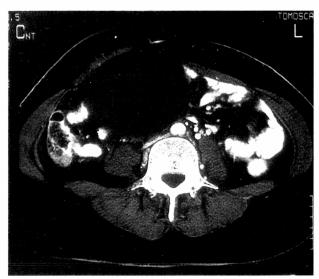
Case 2. A voluminous mass in the right lower quadrant deforming the abdominal wall and the bladder is detectable at computed tomography.
